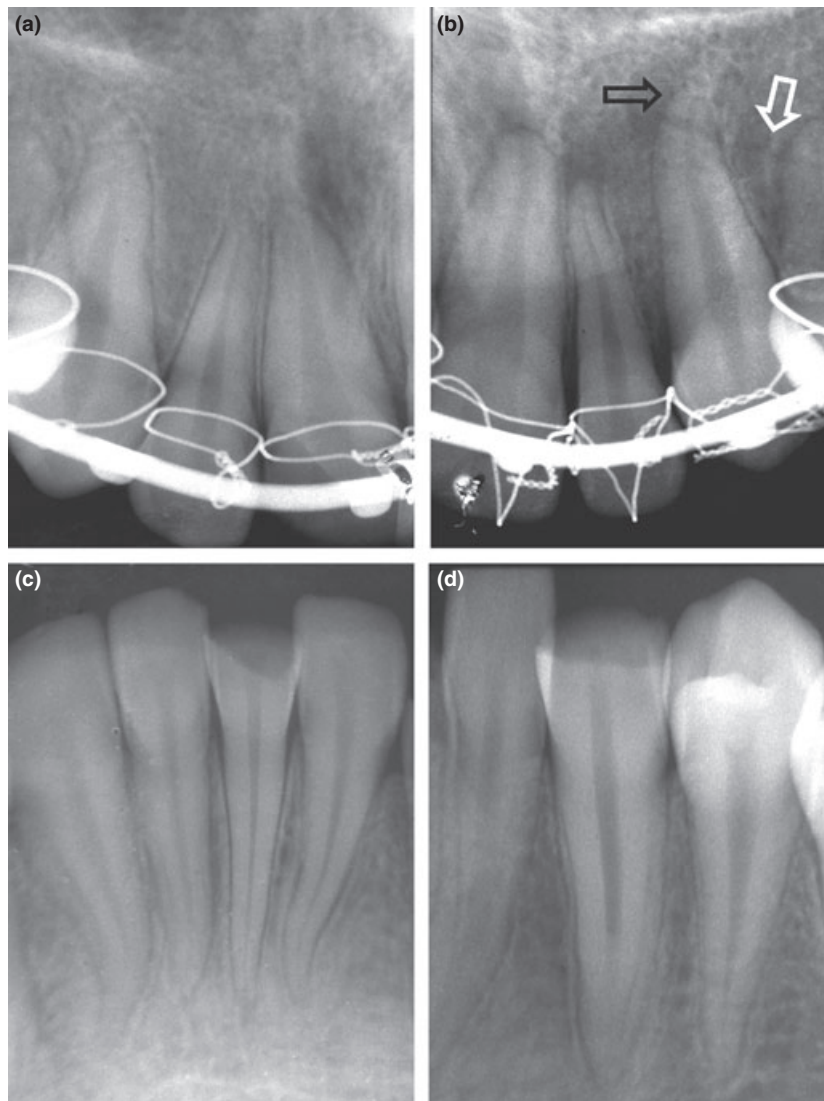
(a) Preoperative radiograph of tooth 11. (b) Preoperative radiograph of the replanted teeth. Note an apical root fracture (black arrow) and an alveolar bone fracture (white arrow). (c) Preoperative radiograph of teeth 31 and 41. (d) Preoperative radiograph of tooth 33 with two roots.
